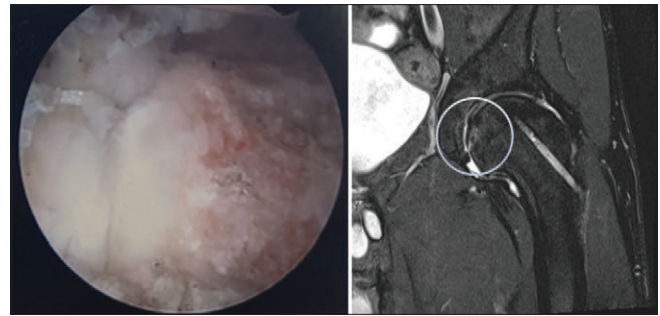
Demonstrates the comparable MRI image to arthroscopic finding of a femoral cartilage wear. MRI: Magnetic resonance imaging
